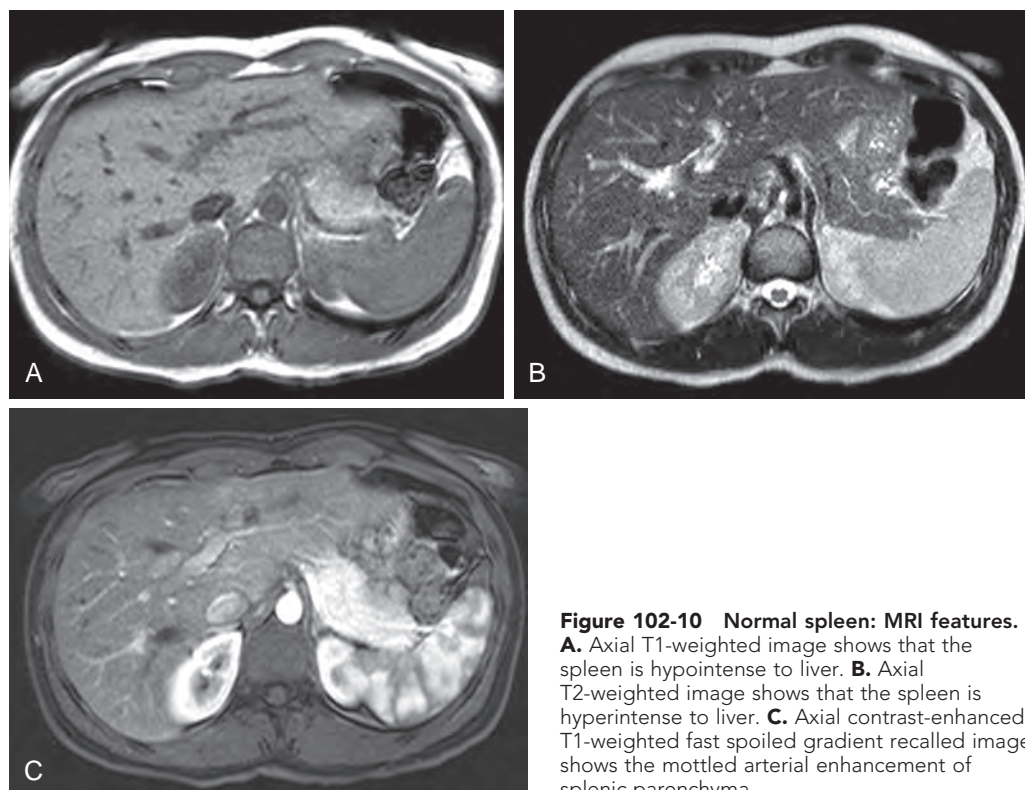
Normal spleen: MRI features.
